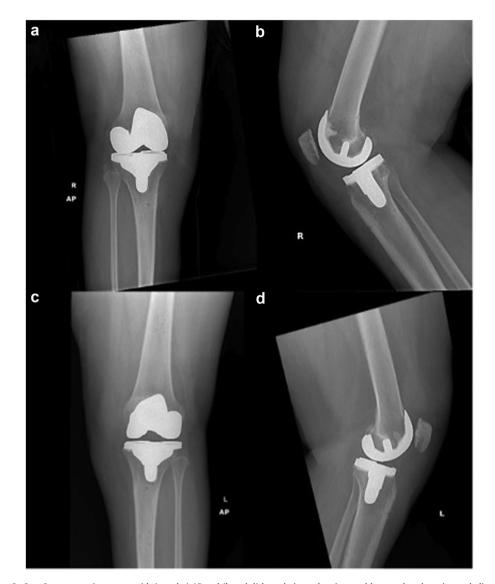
Case 3 postoperative x-rays with (a and c) AP and (b and d) lateral views showing total knee arthroplasty in good alignment.
